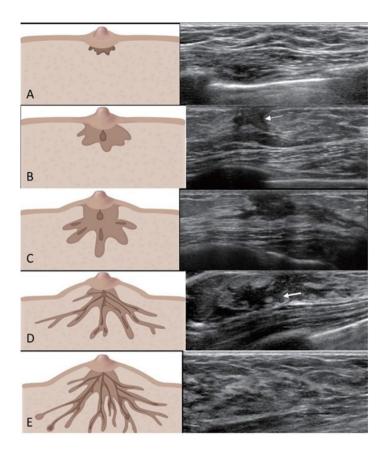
Tanner stages A) Stage 1. Clinically papilla visualized. On ultrasound a small echogenic subareolar area is seen. B) Stage 2. Clinically both the papilla and breast are seen with small enlarged areolar diameter. On ultrasound the subareolar breast bud (thin white arrow) is seen as hypoechoic structure and breast parenchyma, composed of adipose tissues and loose connective tissues are seen as hyperechoic structure. C) Stage 3. Palpable subareolar nodule with enlargement of breast and areola. USG - hyperechoic central spider-like fibroglandular tissue extension with hypoechoic retroareolar ducts systems. D) Stage 4. Secondary mound above the breast is formed. USG shows more widely elongated hypoechoic breast bud and loss of rounded appearance (thick white arrow). Subcutaneous fat is present. E) Stage 5. USG - mature breast showing heterogeneous breast parenchyma with echogenic glandular and stromal tissue. Also noted abundant subcutaneous fat.
